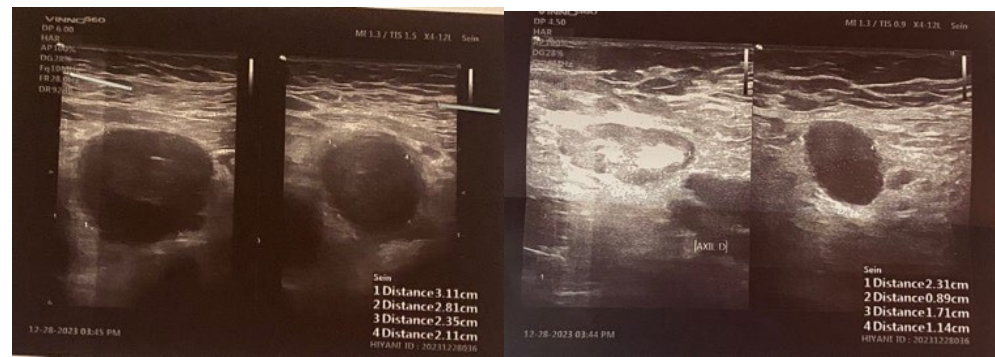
Right breast ultrasound demonstrating multiple hypoechoic masses and axillary lymphadenopathy.
